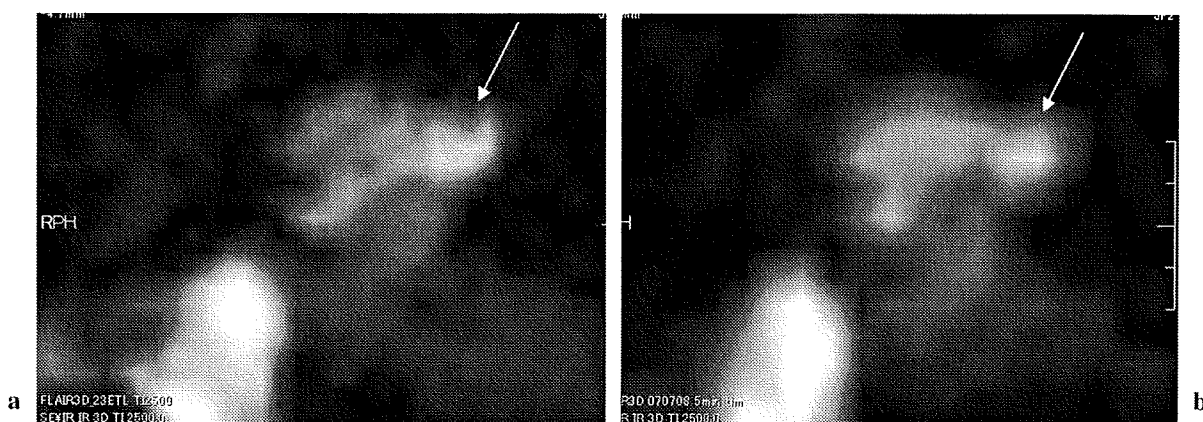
A 50-year-old woman with fluctuating sensorineural hearing loss in the right ear. On 3-dimensional fluid-attenuated inversion recovery using conventional turbo-spin-echo (3D-FLAIR-CONV) (a), the size of endolymphatic space in the cochlea (arrow) was scored as 2; on 3D-FLAIR using variable flip-angle technique (VFL) (b), however, it was scored as 0 (arrow). This is probably due to the lower in-plane resolution and more blurring of 3D-FLAIR-VFL compared with 3D-FLAIR-CONV. The probability of endolymphatic hydrops from clinical records in cochlea was scored as 2.
